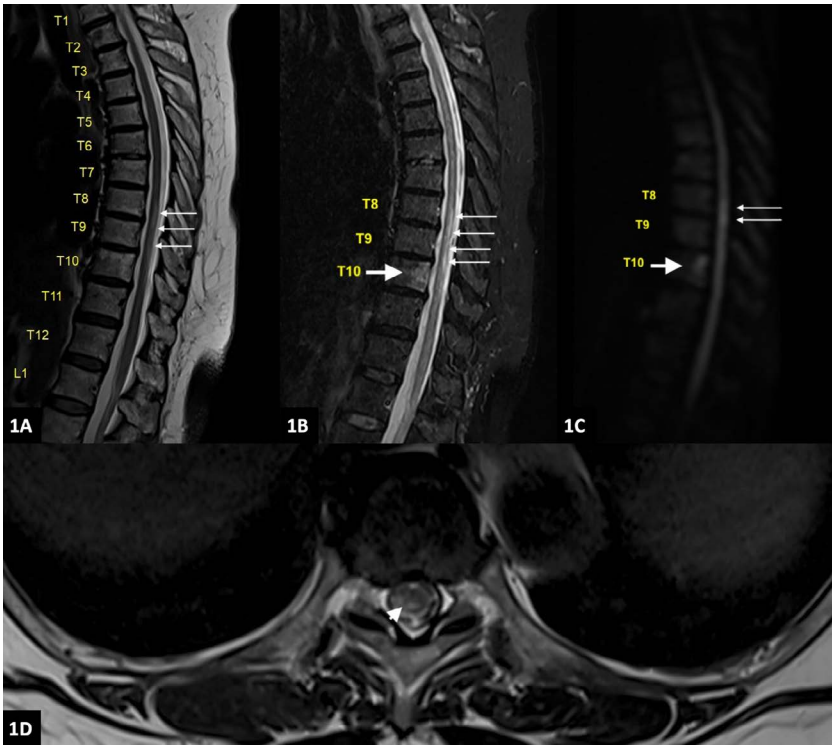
MRI findings. (A) Sagittal T2W, (B) Sagittal STIR, and (C) Sagittal DWI sequences reveal a longitudinal intramedullary hyperintensity spanning the T8–T9 spinal cord levels (thin arrows). (D) Axial T2W image demonstrates patchy hyperintensity within the corresponding segment of the spinal cord (arrowhead). Focal hyperintensity involving the posterior half of the T10 vertebral body is also noted on STIR and DWI sequences (B, C; thick arrows), suggestive of vertebral body infarction.
